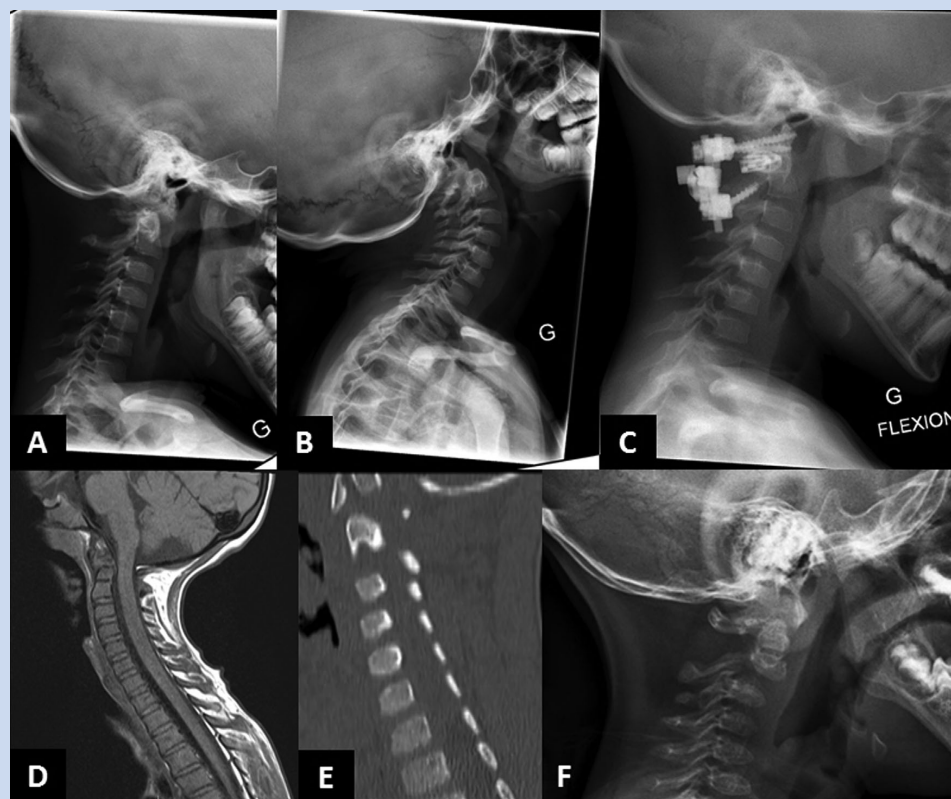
Cervical instability in patients with NBAS deficiency. Panel A, B, and C: radiographs of the cervical spine of patient 1 at age 10 years [B in extension; C after fixation surgery]. Panel D and E: MRI and CT scan of the cervical spine of patient 1 at 10 years. Panel F: radiograph of cervical spine of patient 2 at age 3 years. Note J-shaped sella in both patients (panels C and F) and the small C1 and C2 (all panels) with reduced space around the myelon (panel D).
